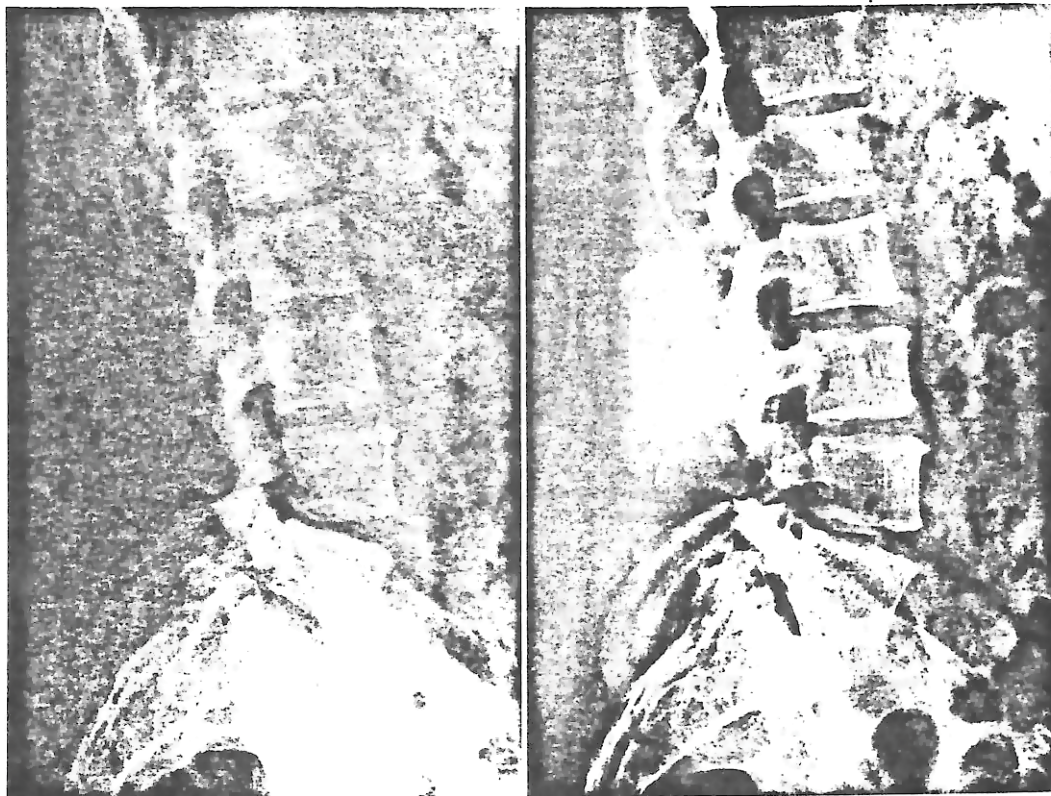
Comparison of lateral lumbosacral spine radiographs at 100 kVp (3 ϕ). The radiation field was 23 X 43 cm. a. Twelve-to-one ratio, 31.5 lines/cm, fiber interspace grid using 100 mA at 0.8 sec., 102-cm source-to-image receptor distance, 2.2 R (0.57 mC/kg) entrance skin exposure, 1.4-mm focal spot size.
